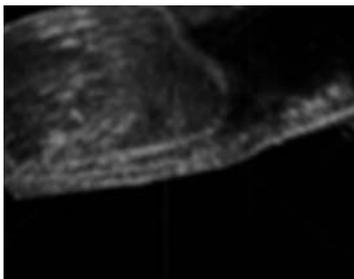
Tumor (arrow) of the monitor ultrasonography was sometimes influenced by multi-reflections, rib shadows and intestinal gas.
